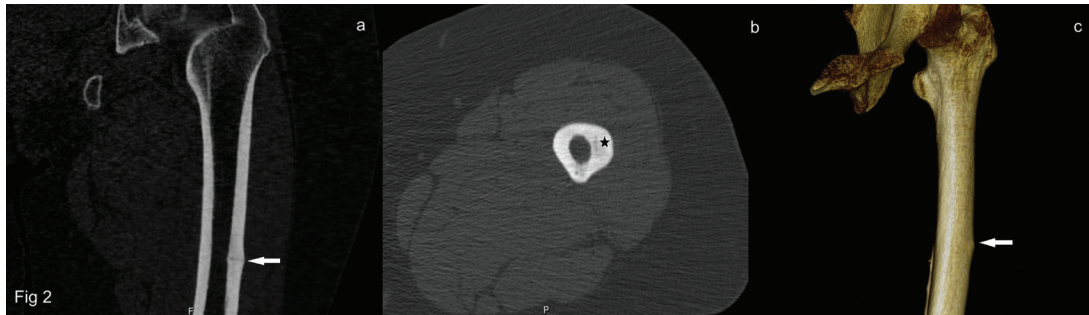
In a, non-displaced and incomplete fracture line (arrow) is detected in coronal non-enhanced and reformatted CT image, b, axial non-enhanced CT image shows discrete radiolucency (star) on the fracture site, c, The cortical thickening (arrow) on the lateral cortex can be easily seen in VRT - CT (Volume Rendering Technique- Computerized Tomography) image.
